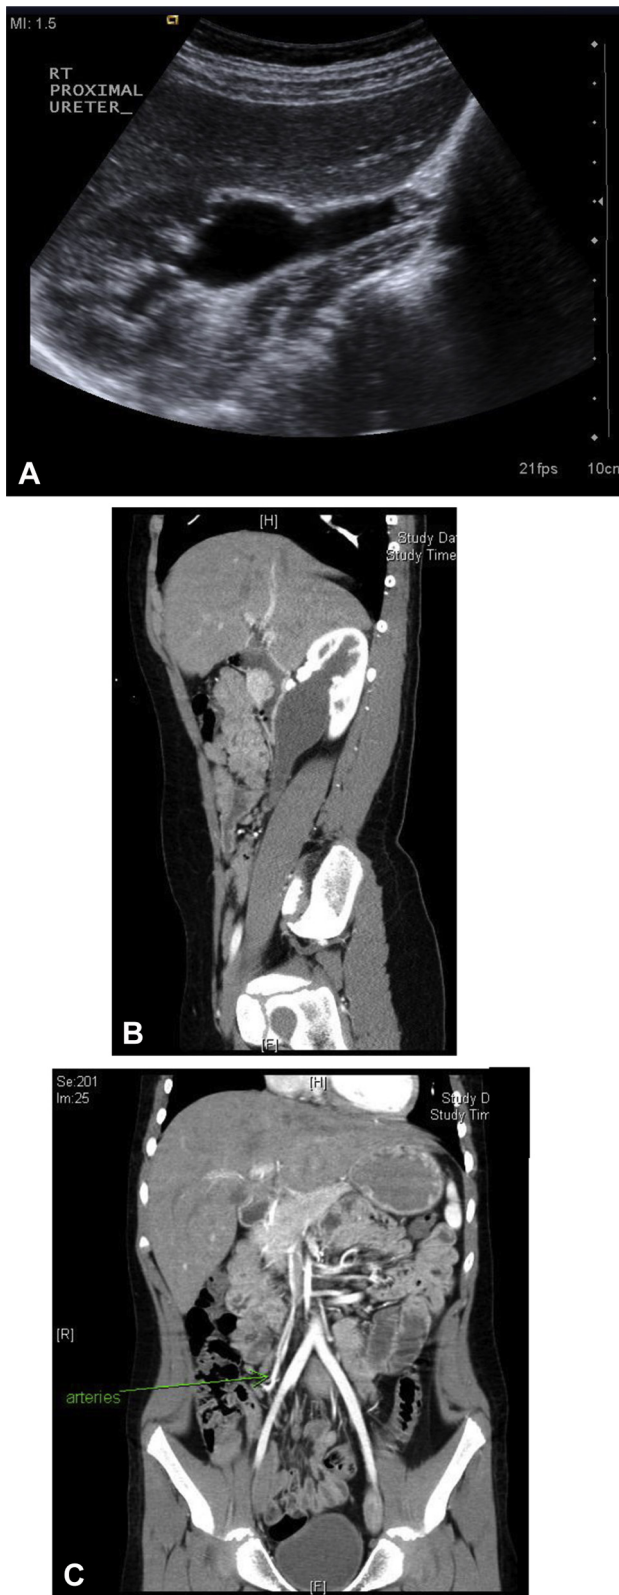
US & CT images of FEP: (A) Sonographic image demonstrating the FEP. (B) Sagittal CT angiogram demonstrating right pelvic fullness with proximal ureteral dilatation at the level of L5. (C) Coronal CT angiogram demonstrating crossing vessels from the celiac and SMA noted at this level. Coronal image through the renal pelvis shows mild hydronephrosis with dilatation of the renal pelvis and proximal ureter down to the non-shadowing irregular ureteral filling defect (FEP) that measures 0.54 cm in diameter and is indicated by the arrow. The right kidney measures $9.50 \times 3.60 \times 3.17$ cm.
